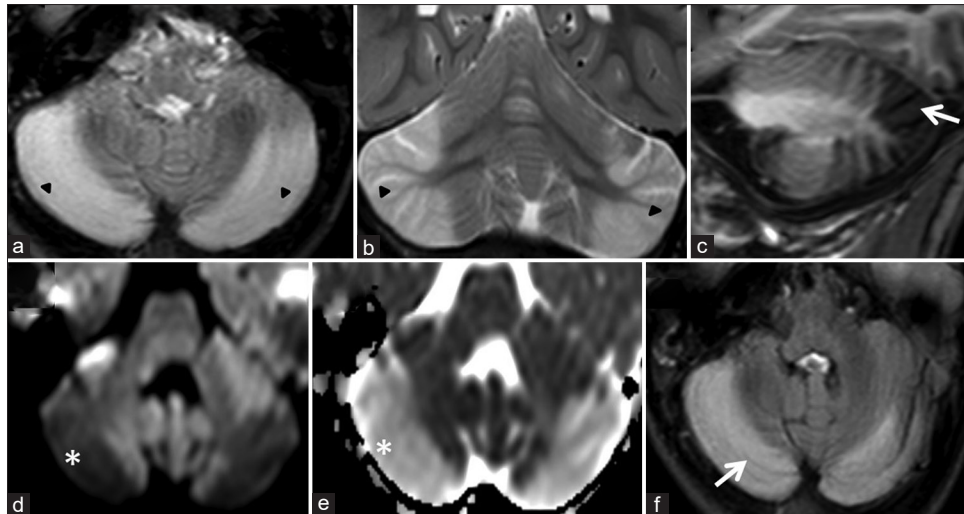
Axial, coronal T2-weighted images (a, b) show bilateral symmetrical hyperintensity involving the cerebellar cortex (black arrowheads). Posterior predominance noted on sagittal T1-weighted image (white arrow in c). Diffusion-weighted images (d) and apparent diffusion coefficient (e) show facilitated diffusion (asterisk in d, e). T2 FLAIR image (f) on follow-up shows persistent signal changes with mildly prominent foliae (white arrow in f) suggestive of cerebellar atrophy
